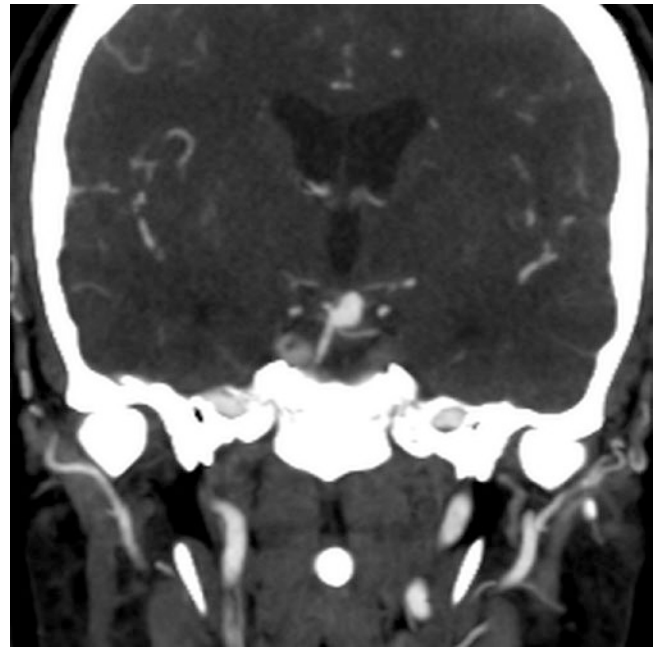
Basilar tip aneurysm. Coronal CTA demonstrates a superiorly projecting aneurysm from the distal basilar artery. The neck is located between the origins of left posterior cerebral artery and superior cerebellar artery
